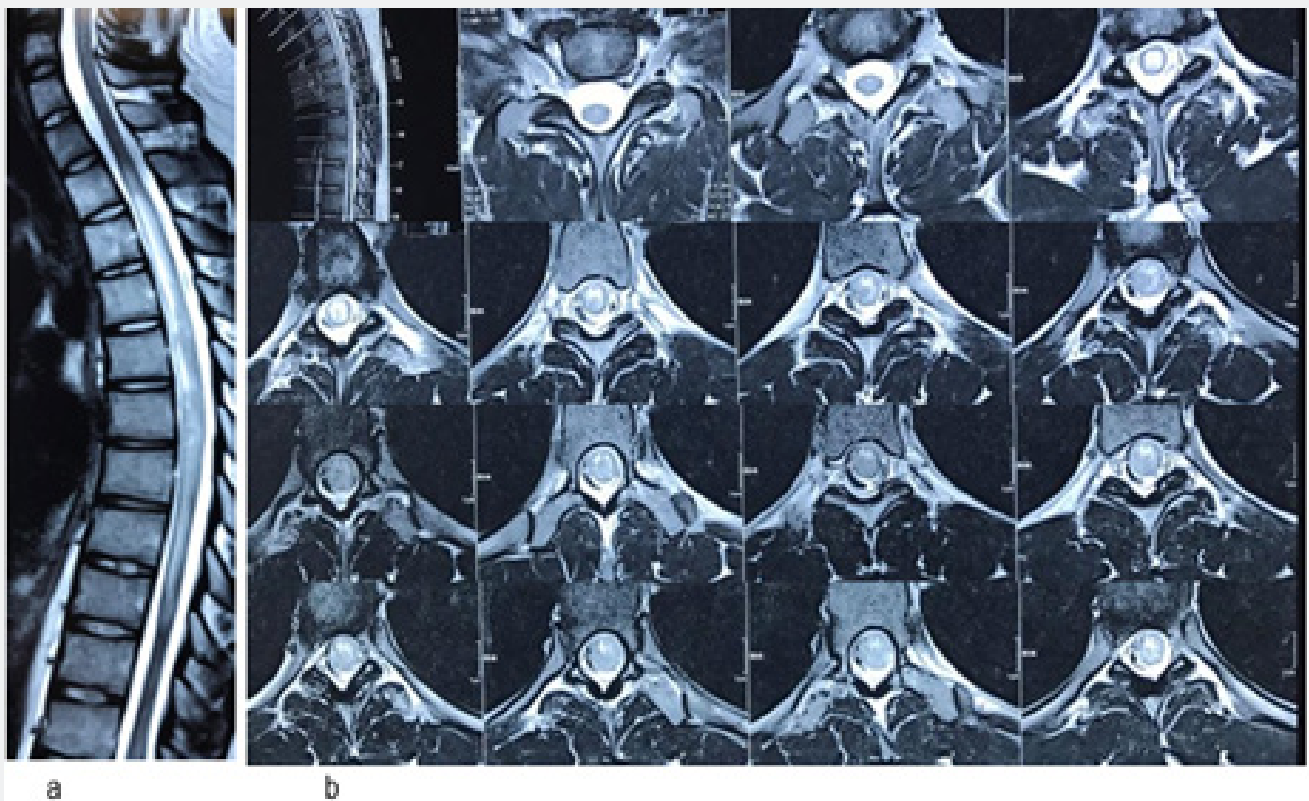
MRI spine, midline sagittal (a), serial axial sections showed thoracic segment 2 to 9 longitudinally extensive intramedullary lesion.
